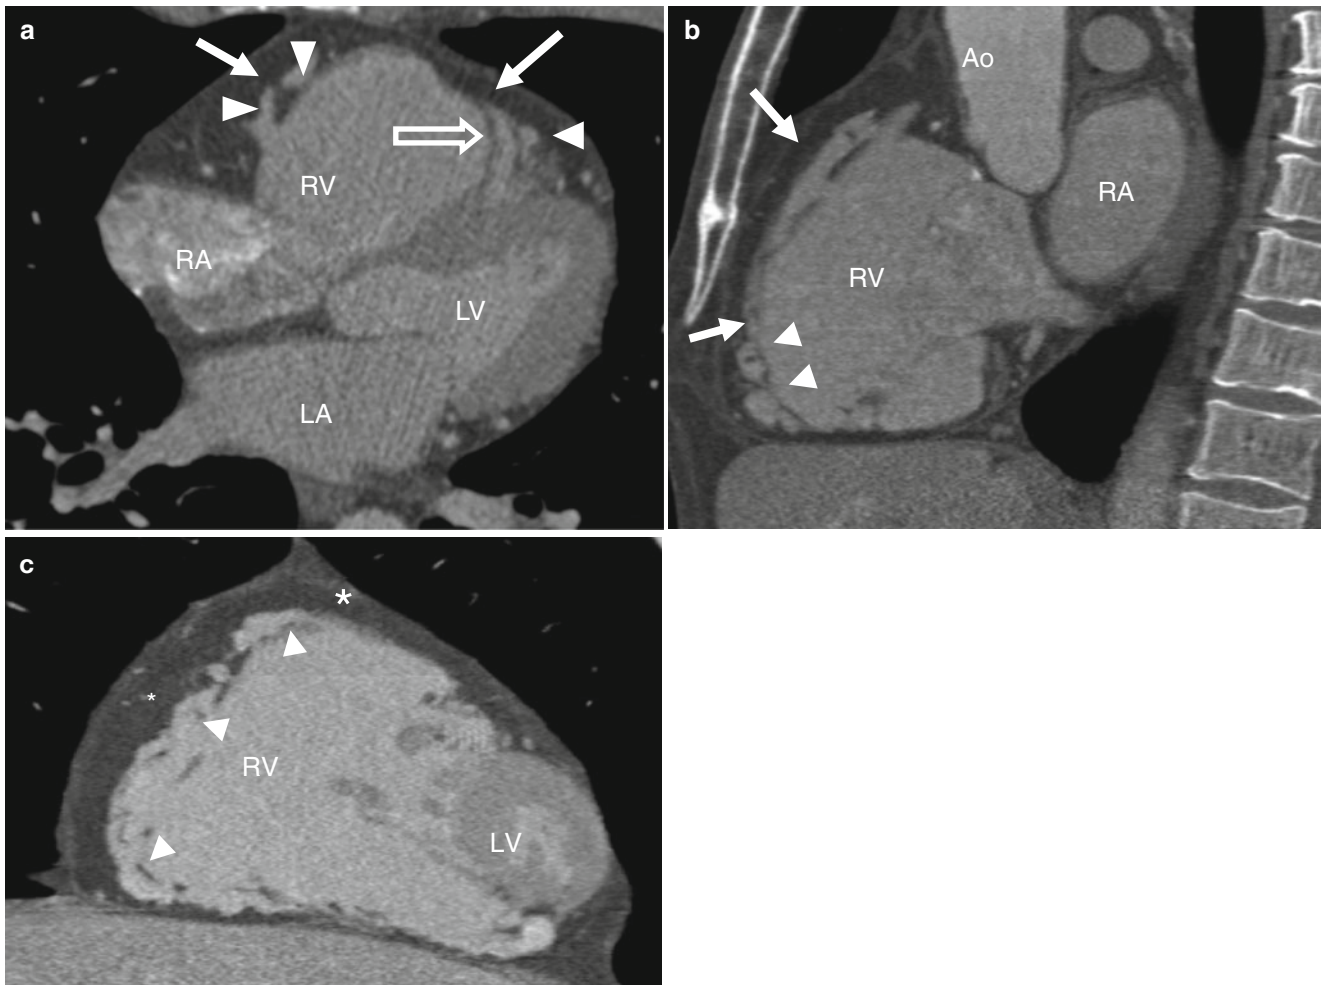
Panel (a): an axial computed tomographic (CT) image in an arrhythmogenic right ventricular dysplasia (ARVD) patient demonstrating profound right ventricle dilatation, extensive low-attenuation fatty tissue in the wall of the right ventricle (*white arrows*), and prominent trabeculae (*white arrowheads*). Fatty tissue is also seen in the moderator band (*open arrow*). Panels (b) and (c) are
